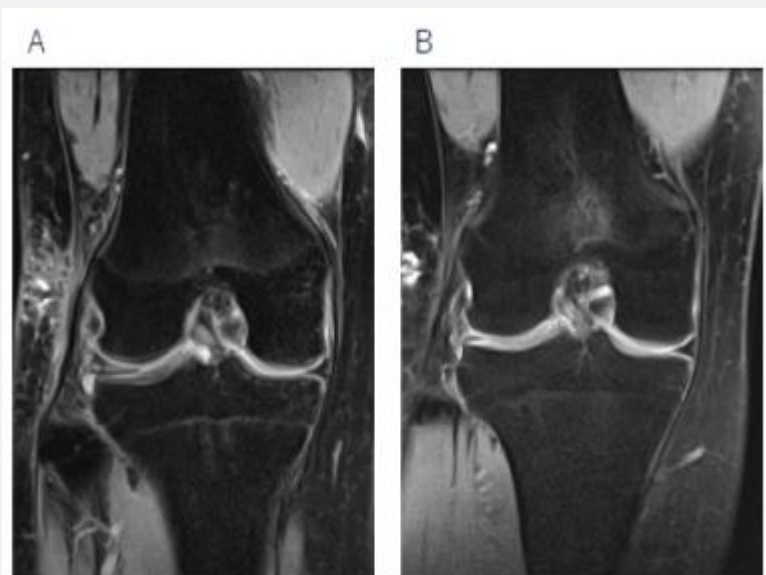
MRI showing a repaired lateral meniscus with a horizontal rupture in the anterior segment, a degenerative rupture in the middle portion, and a longitudinal rupture in the posterior segment. Echo picture with T2-weight gradient.
